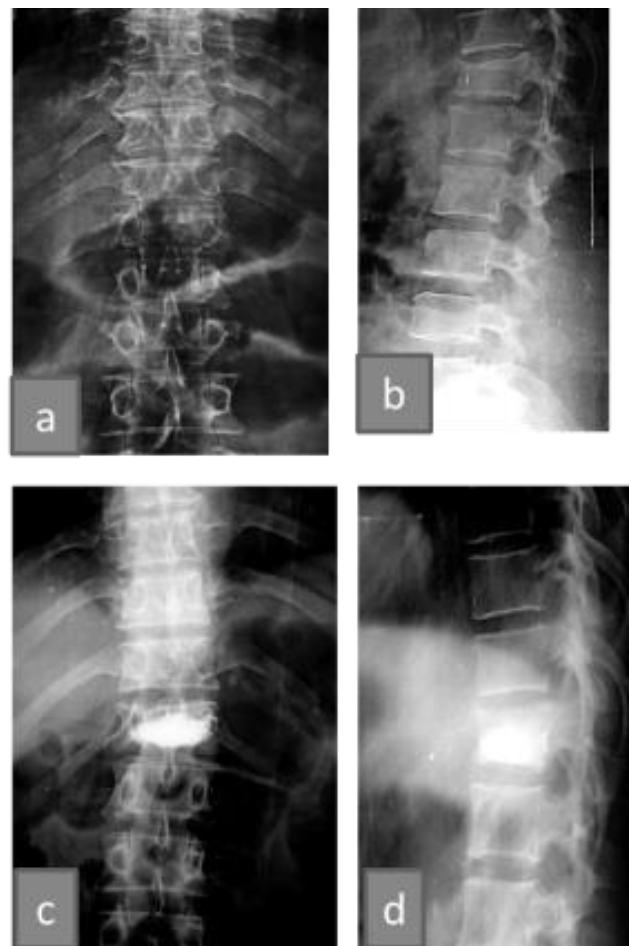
Pre- and post-operative x-ray AP & lat view
